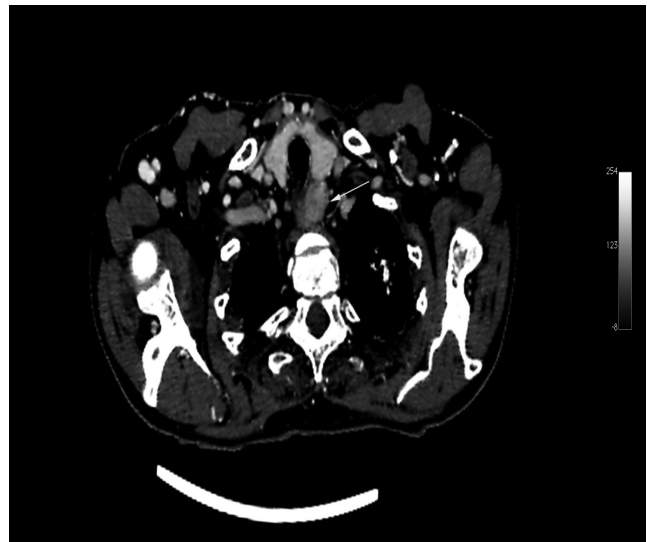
Axial contrast enhanced computed tomography shows homogeneous, hyperdense, well-defined 2-cm-diameter nodules (arrow) adjacent to the lower pole of the left thyroid lobe
